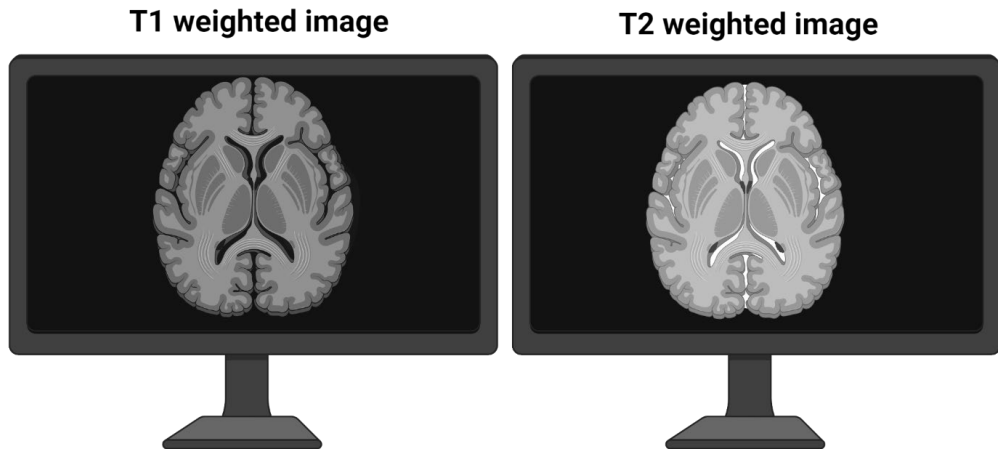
T1- and T2-weighted images (Paper I)
